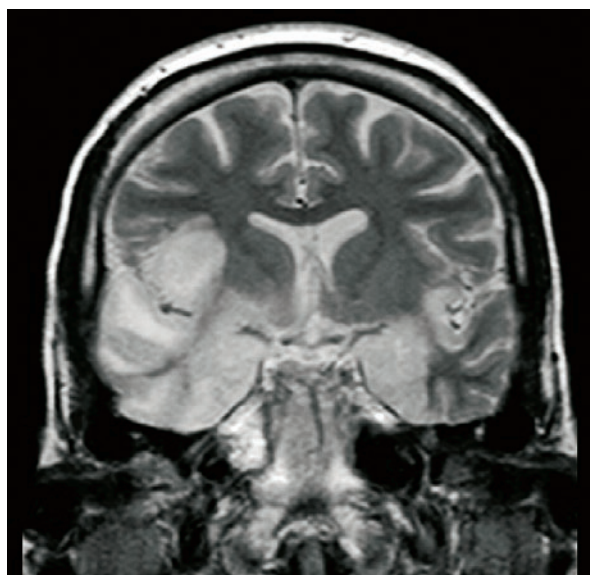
MRI of brain, coronal view in T2 WI. Display of hyperintense signal in the temporal lobes, extending to the hippocampus and the lower right frontal gyrus.
